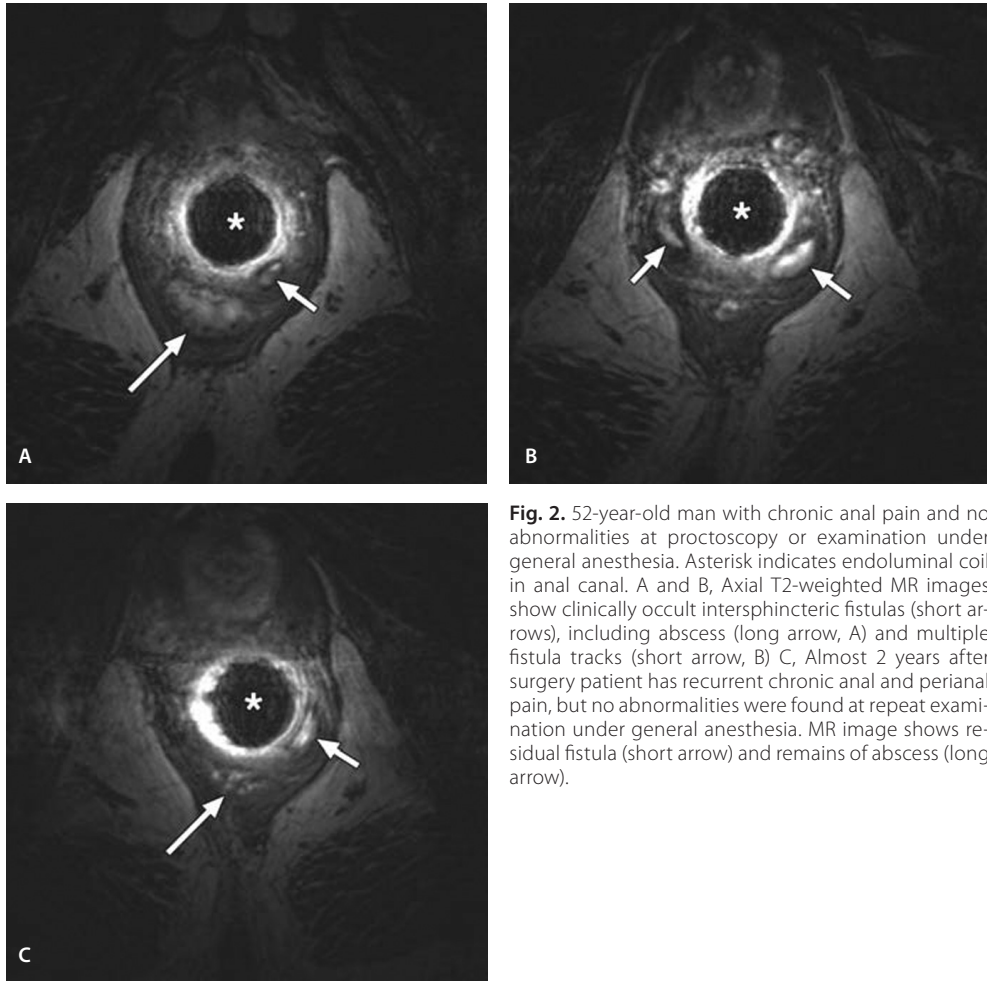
52-year-old man with chronic anal pain and no abnormalities at proctoscopy or examination under general anesthesia. Asterisk indicates endoluminal coil in anal canal. A and B, Axial T2-weighted MR images show clinically occult intersphincteric fistulas (short arrows), including abscess (long arrow, A) and multiple fistula tracks (short arrow, B) C, Almost 2 years after surgery patient has recurrent chronic anal and perianal pain, but no abnormalities were found at repeat examination under general anesthesia. MR image shows residual fistula (short arrow) and remains of abscess (long arrow).
